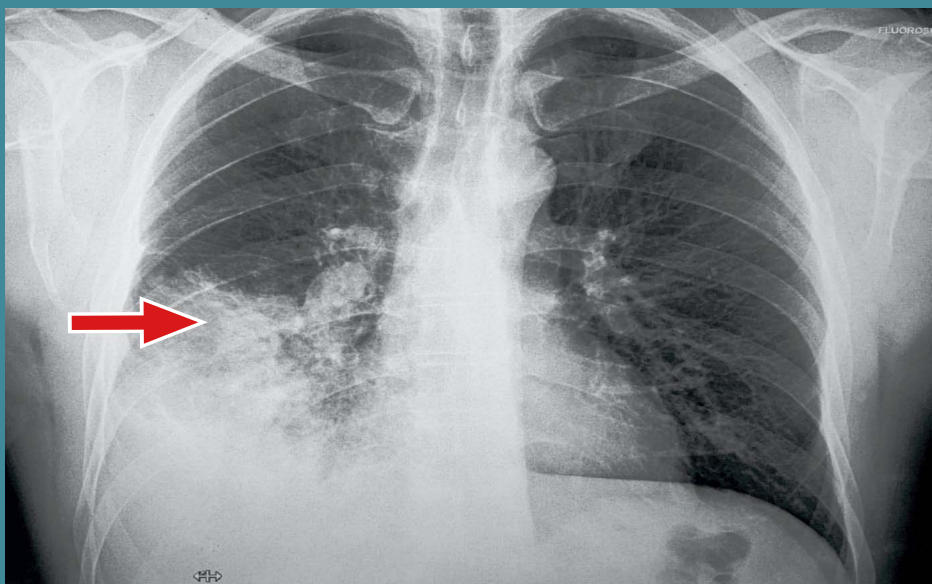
Chest X-ray (August 2018) showing a non-uniform, unsystematized opacity, of medium intensity, located at the level of the right lung field in the lower half
